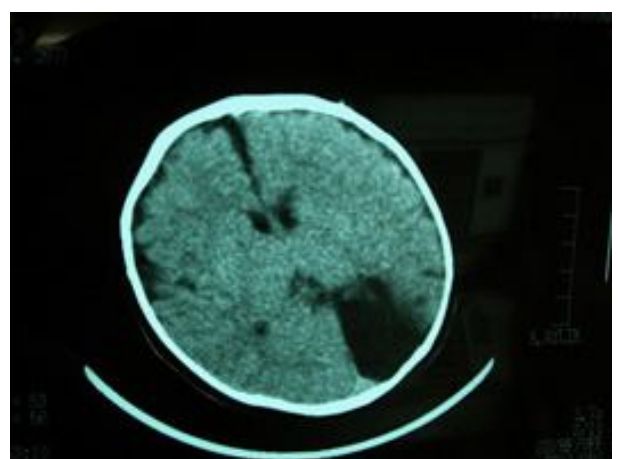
Cranial CT scan of a patient in the follow-up period presenting with encephalomalastic area secondary to intraparenchymal hemorrhage.
